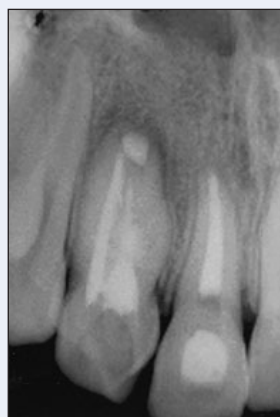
Radiograph taken at 3 months follow-up.
